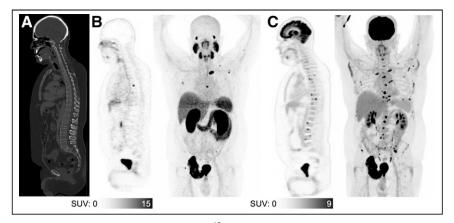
Exemplary patient who showed ¹⁸F-FDG/PSMA mismatch that was not detected by PSMA-only analysis. PSMA-11 PET/CT showed no significant CT correlate of bone lesions (A), which have high PSMA uptake (B). However, ¹⁸F-FDG PET/CT showed more than 20 additional bone lesions (C).
